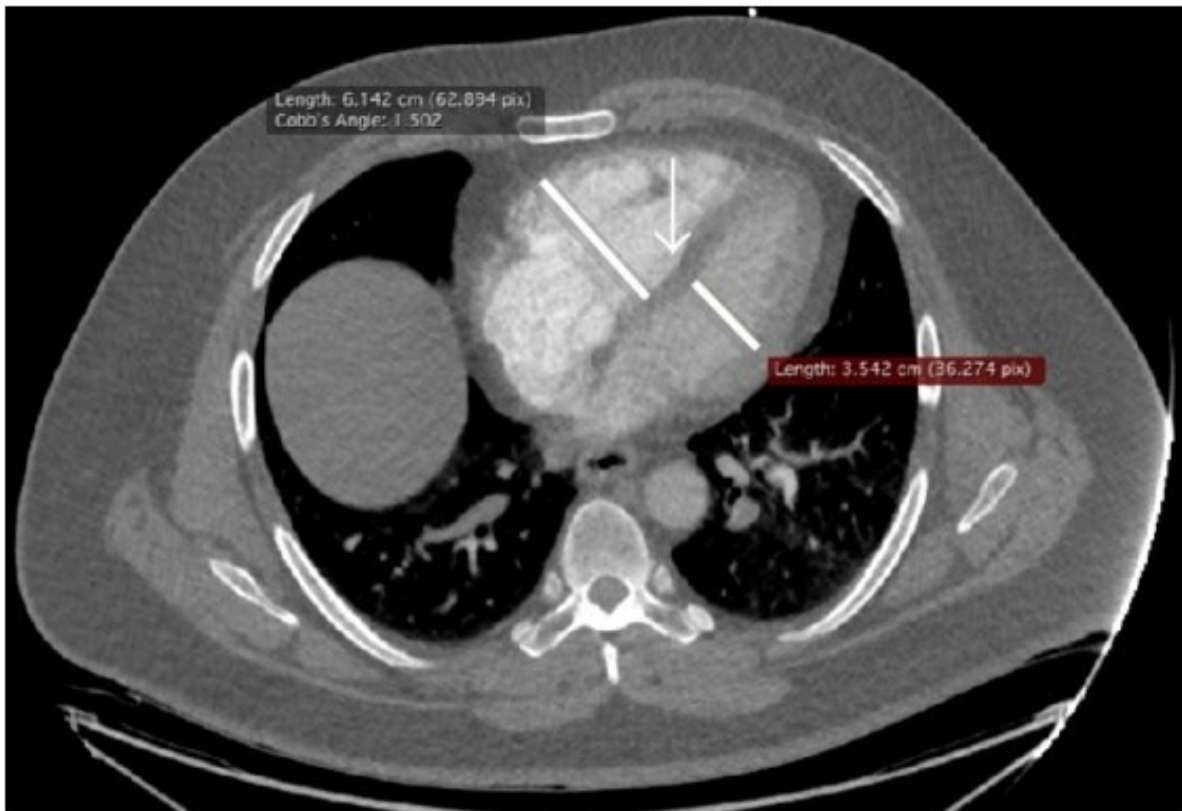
CT of a 75-year-old man with RV dysfunction showing increased right-to-left diameter ratio (113).
